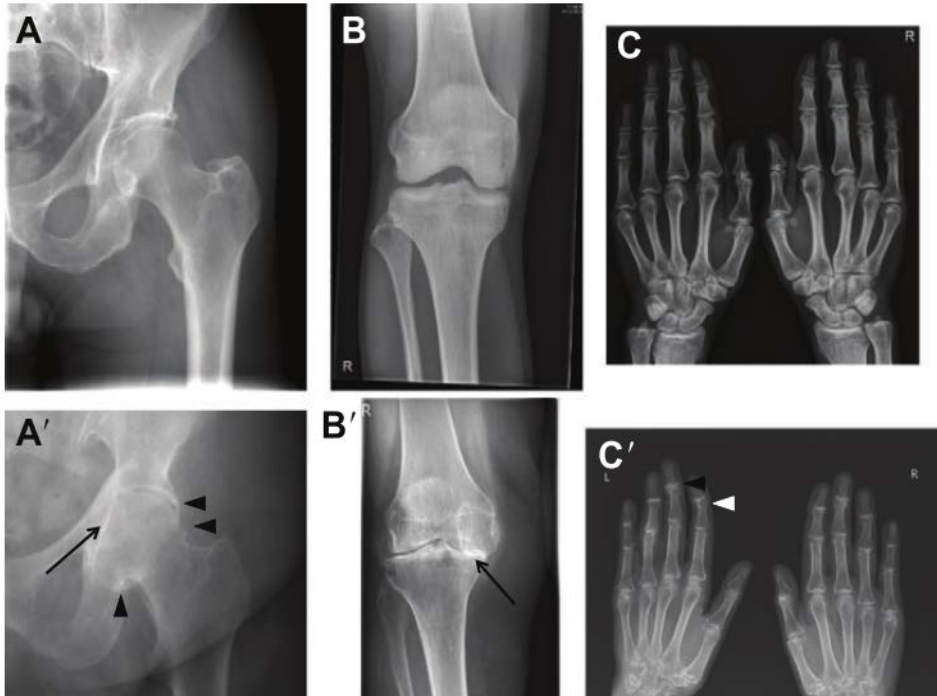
X-ray radiographic images showing structural alterations of the joints most commonly affected by osteoarthritis. (A, B, C) Normal and (A', B', C') severely affected joints of the hip, knee and hand, respectively. Arrows indicate joint space narrowing; arrowheads indicate the presence of osteophytes (bony outgrowths) (Thysen et al., 2015).
